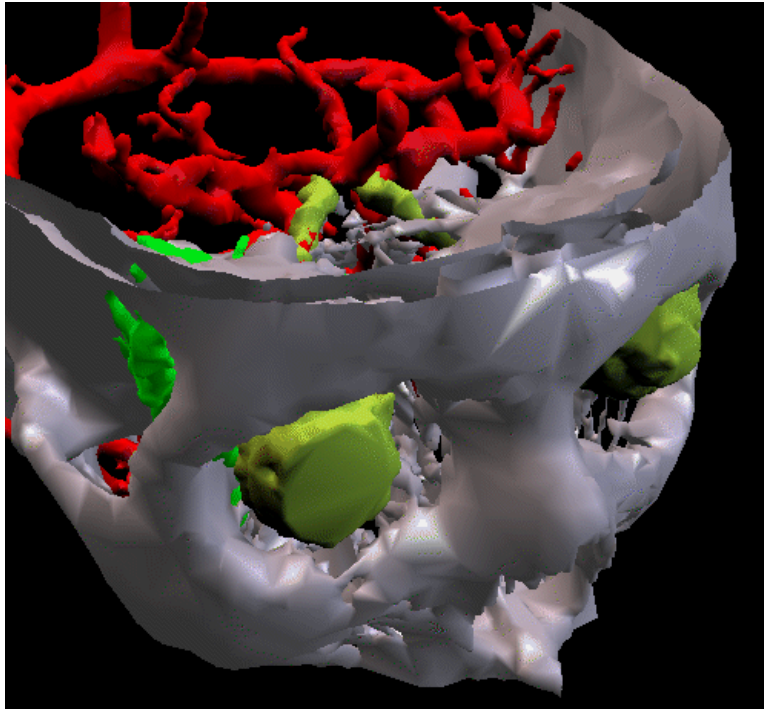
Right frontal view of the 3D model. The skull (colored white) is derived from CT images, while the vascular tree (red) was derived from an MR angiogram. Models of the tumor (green) and optic nerve with the ocular bulb (yellow) were derived from an gradient echo MR sequence.
